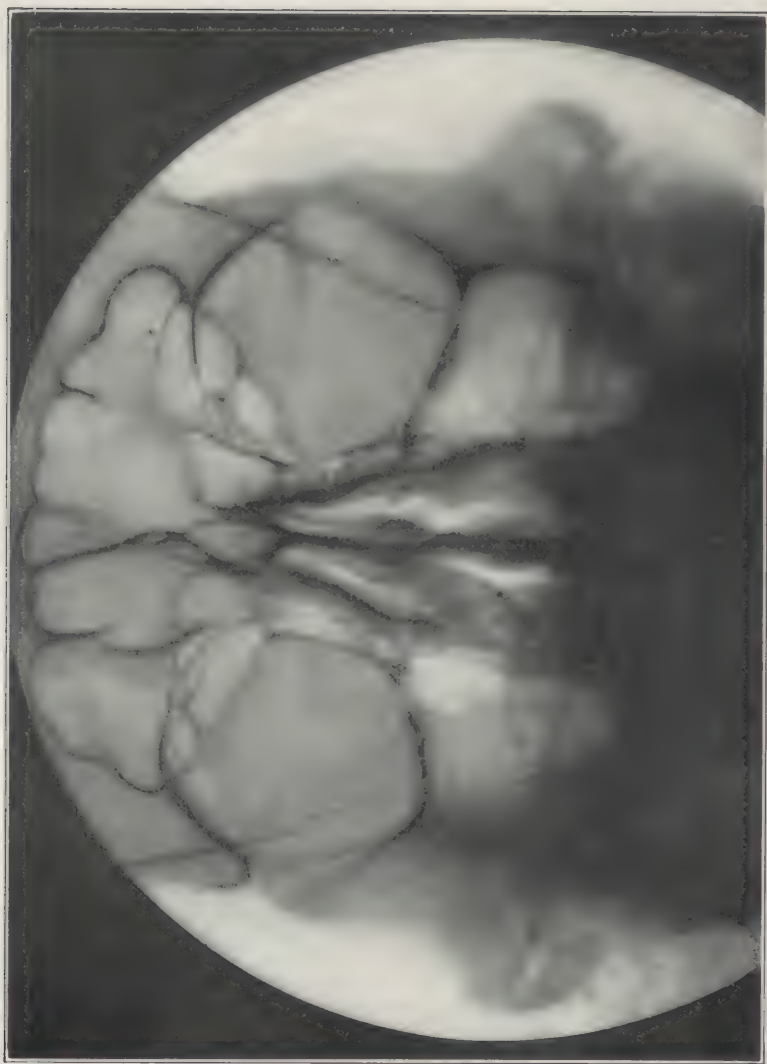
This X-ray plate is of a very pneumatic head. The frontal sinuses are extremely large. The right frontal sinus looks double, the appearance is due to a heavy ridge. There are large orbito-frontal cells and the crista galli has a large cell. The antra are well developed.
